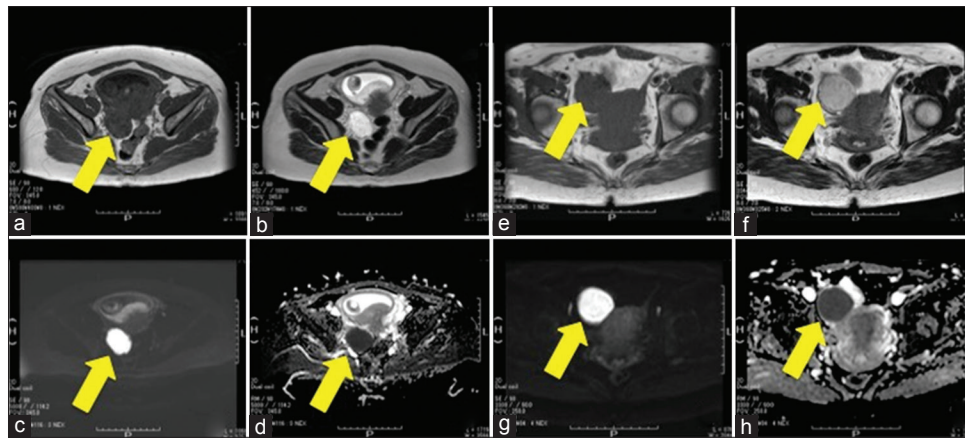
Magnetic resonance imaging studies of the pelvis in the present case. (a), (b), (c), and (d) Magnetic resonance imaging performed at 12 weeks of gestation. (e), (f), (g), and (h) magnetic resonance imaging performed at 2 months after delivery. (a) Axial T1-weighted image showing an enlarged right ovary (arrow) with iso intensity to low intensity. (b) Axial T2-weighted image showing an enlarged right ovary (arrow) with relatively high intensity. (c) Axial diffusion-weighted imaging showing an enlarged right ovary (arrow) with increased signal intensity. (d) Axial apparent diffusion coefficient showing an enlarged right ovary (arrow) with low-signal intensity. (e) Axial T1-weighted image showing an enlarged right ovary (arrow) with iso intensity to low intensity. (f) Axial T2-weighted image showing an enlarged right ovary (arrow) with somewhat lower intensity than the image presented in (b). (g) Axial diffusion-weighted imaging showing an enlarged right ovary (arrow) with high-signal intensity. (h) Axial apparent diffusion coefficient showing an enlarged right ovary (arrow) with low-signal intensity
